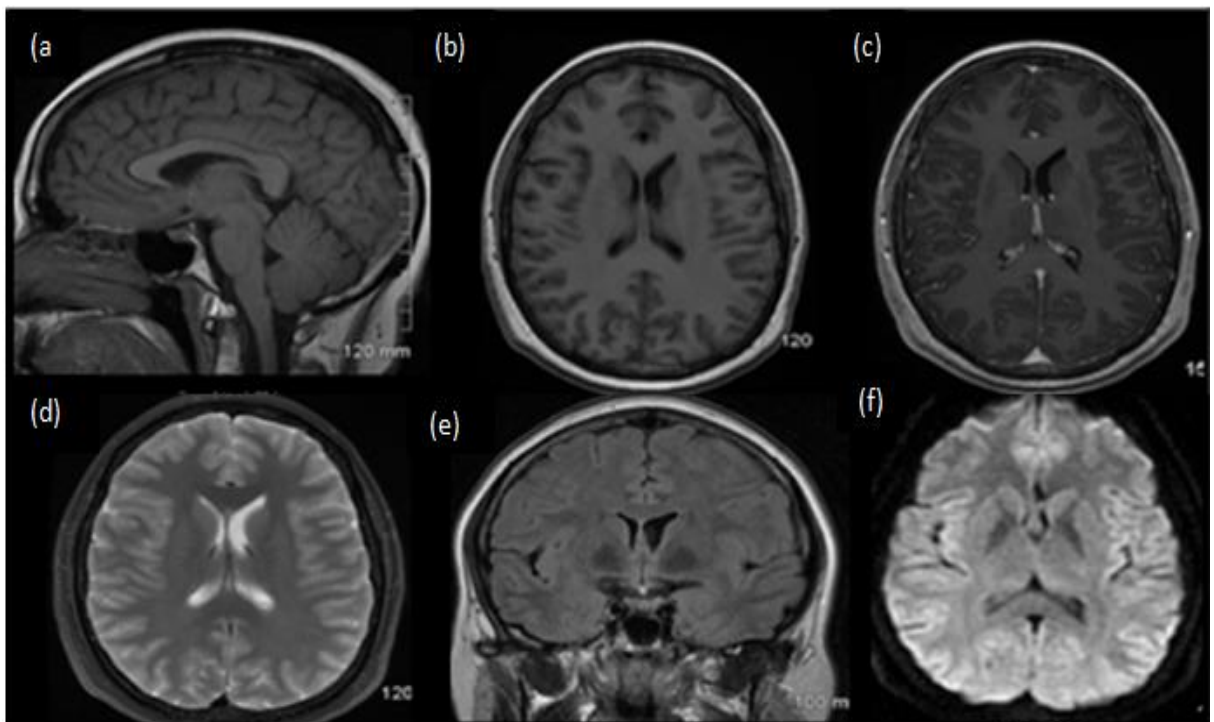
Comparative visual demarcation between most frequently used sequences i.e. T1, T2, FLAIR and DWI in MR Brain images of a patient. (a) Sagittal T1 for evaluating midline structures (b) Axial T1 for evaluating anatomic detail (c) axial T1 with contrast for evaluating BBB breakdown (d) Axial T2 for looking at areas of edema and pathology (e) Coronal FLAIR for evaluating edema with CSF (f) Axial DWI for stroke imaging, abscess, cellular tumors.
